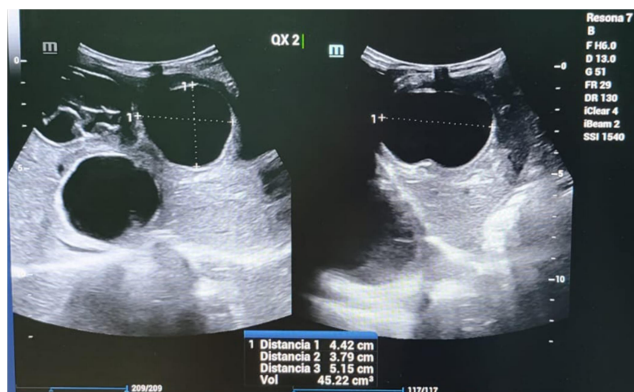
Two cysts are observed at the level of segments I and IV, according to Couinaud's anatomy. These lesions are round with well-defined borders, anechoic with posterior acoustic enhancement, and show no vascular flow upon color Doppler evaluation. These findings are consistent with hydatid cysts in the CE1 stage.
